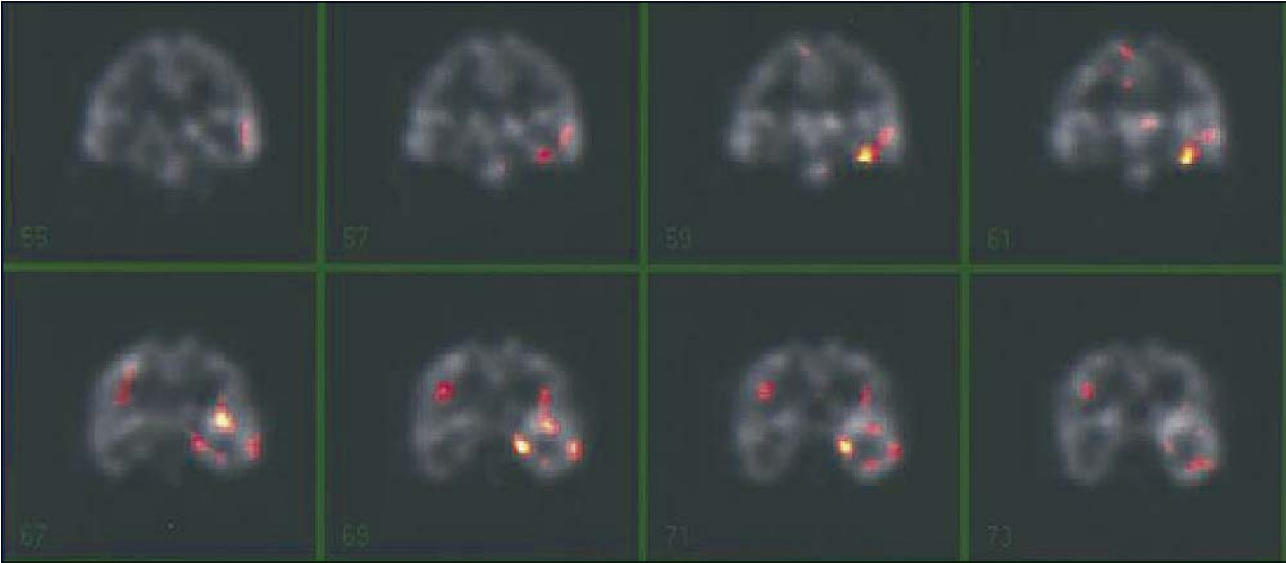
Ictal SPECT hyperfusion in the left infero-mesial temporal and insular regions.
